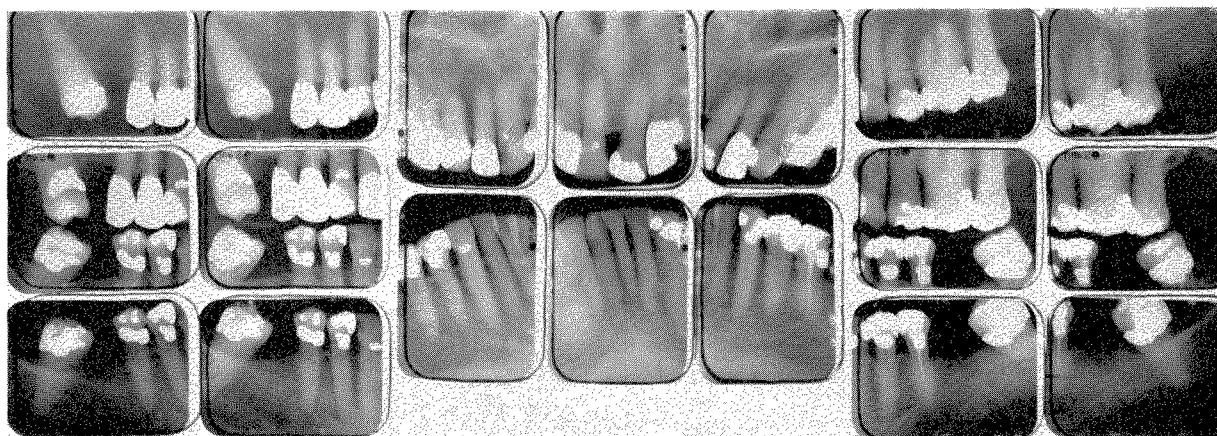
Roentgenograms taken of the patient in November, 1961, at the age of 83.
